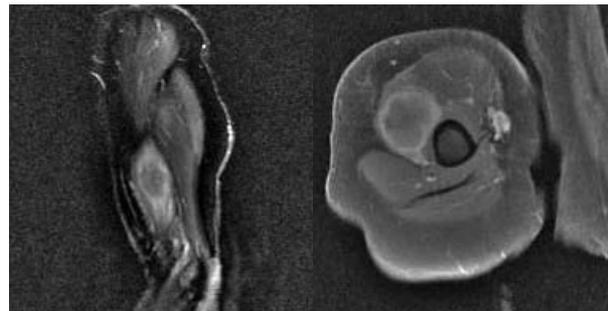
MRI humerus FSE IR sagittal view
